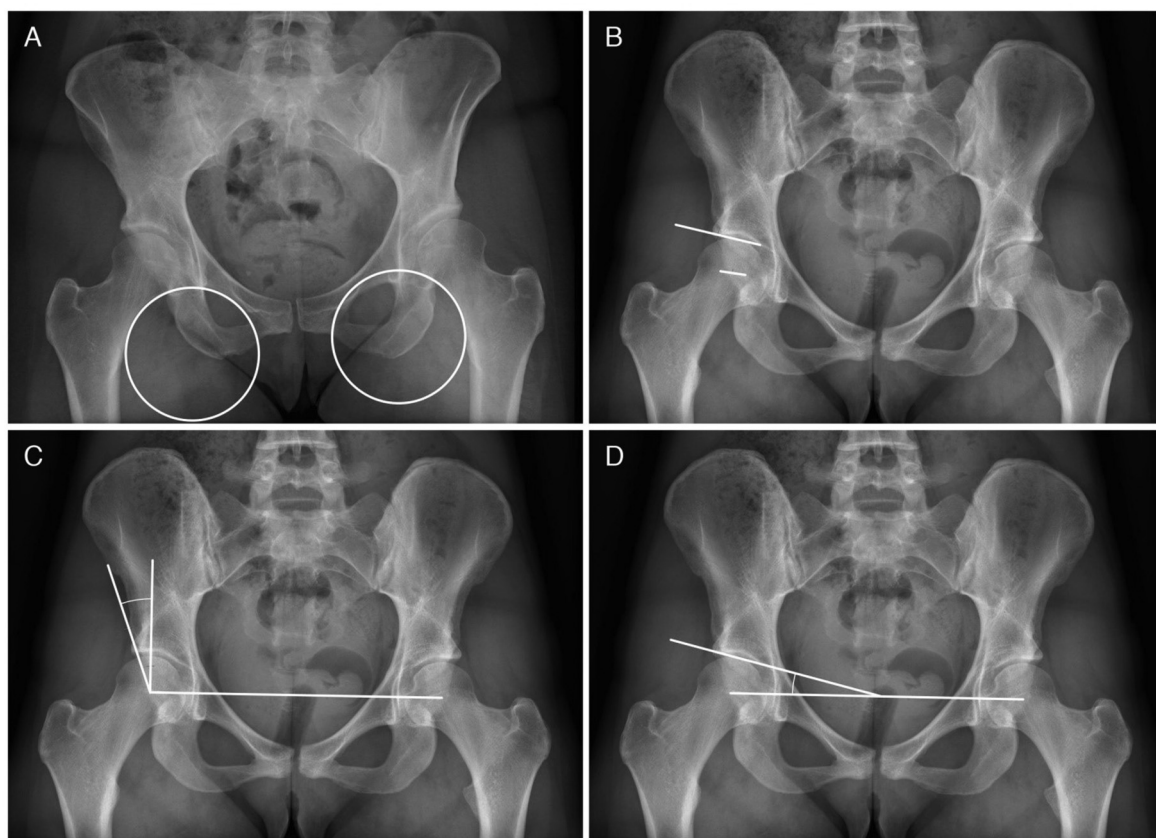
Radiographic measurement of (a) a broken Shenton's line on the left hip, (b) the FEAR index, (c) the CE angle, and (d) the AI angle. AI, acetabular index; CE, center-edge; FEAR, Femoral-Epiphyseal Acetabular Roof.
